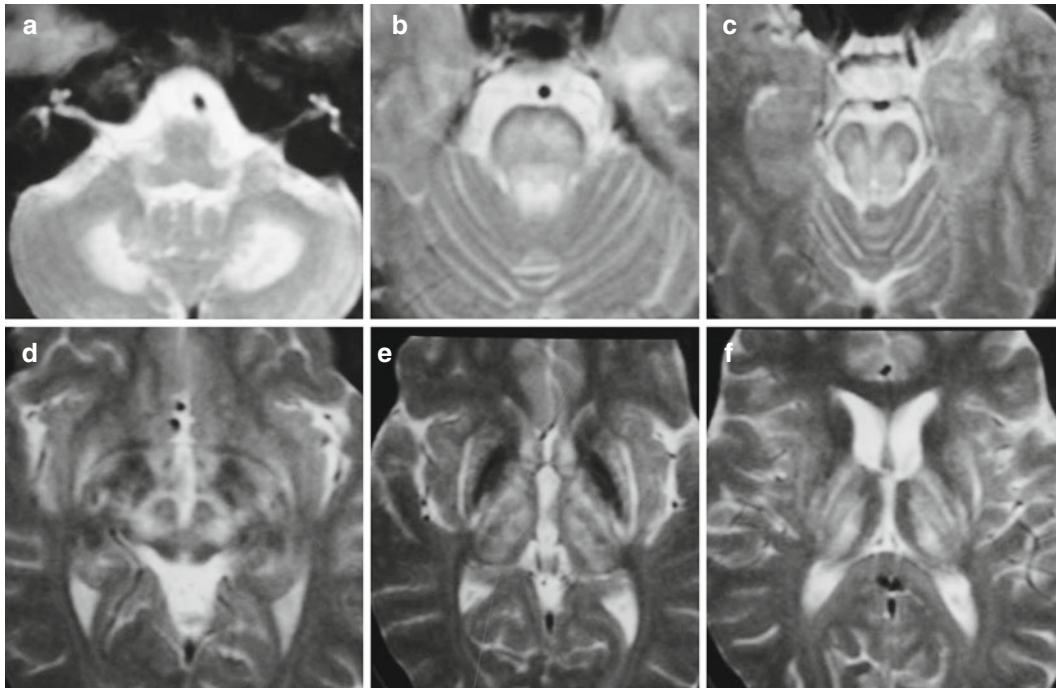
Wilson Disease. Axial T2-weighted images, a-f, show the typical findings of the disease. Hyperintensity is observed in the cerebellar white matter, a, and in the pons with sparing of the peripheral profile, b. In the mid-brain, hyperintensity with sparing of red nuclei, reticular portion of substantia nigra and superior collicula produce
